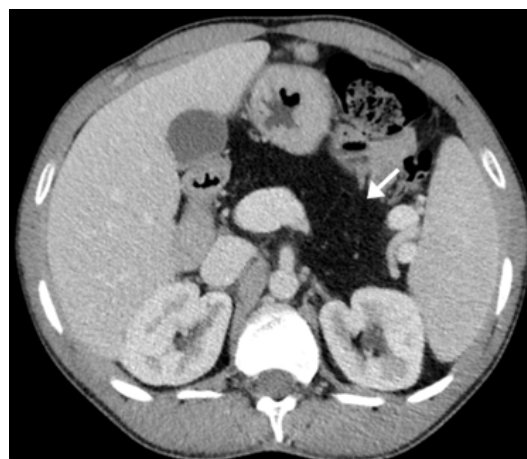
CT image shows an enlarged pancreas (arrow) with diffuse fat density. There is also splenomegaly and portal vein enlargement, evocative of portal hypertension.
